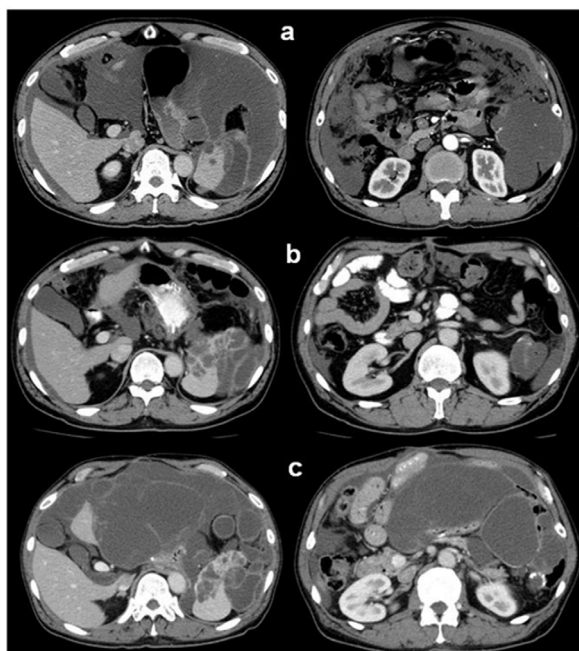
Enhanced abdominal CT scans throughout treatment. (a) Before the first operation. (b) After chemotherapy, demonstrating the reduction of ascites. (c) Before the third operation.
